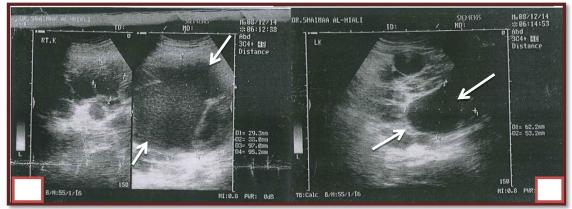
Abdominal ultrasonography image for a 40 year old patient with ADPKD showing remarkably enlarged kidneys' size with multiple cysts. The largest cysts was on the right kidney with 10*10cm in diameter with few stones of less than 5mm in diameter (A) and the largest cysts was on the left kidney with 6.3*5.3cm in diameter (B).
